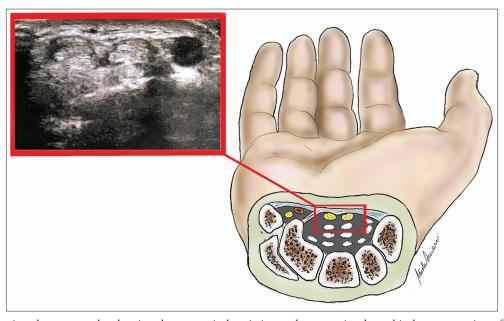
Preoperative ultrasonography showing the anatomical variation and an associated graphical representation of the bifid median nerve at the carpal tunnel.
